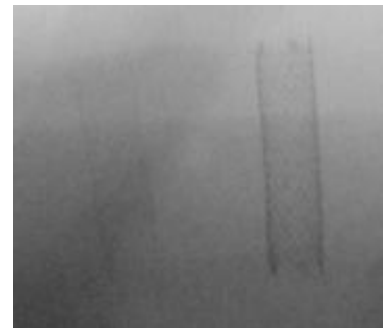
X-ray image of a bare Nitinol stent on the left (faint) and a Nitinol stent with a 10 μm coating of Ta.
